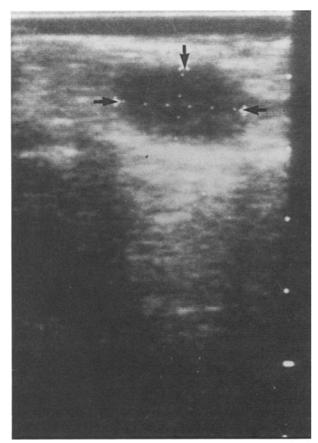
Ultrasonographic patterns (arrows) of insulinoma: hypoechogenic mass of pancreatic body.
